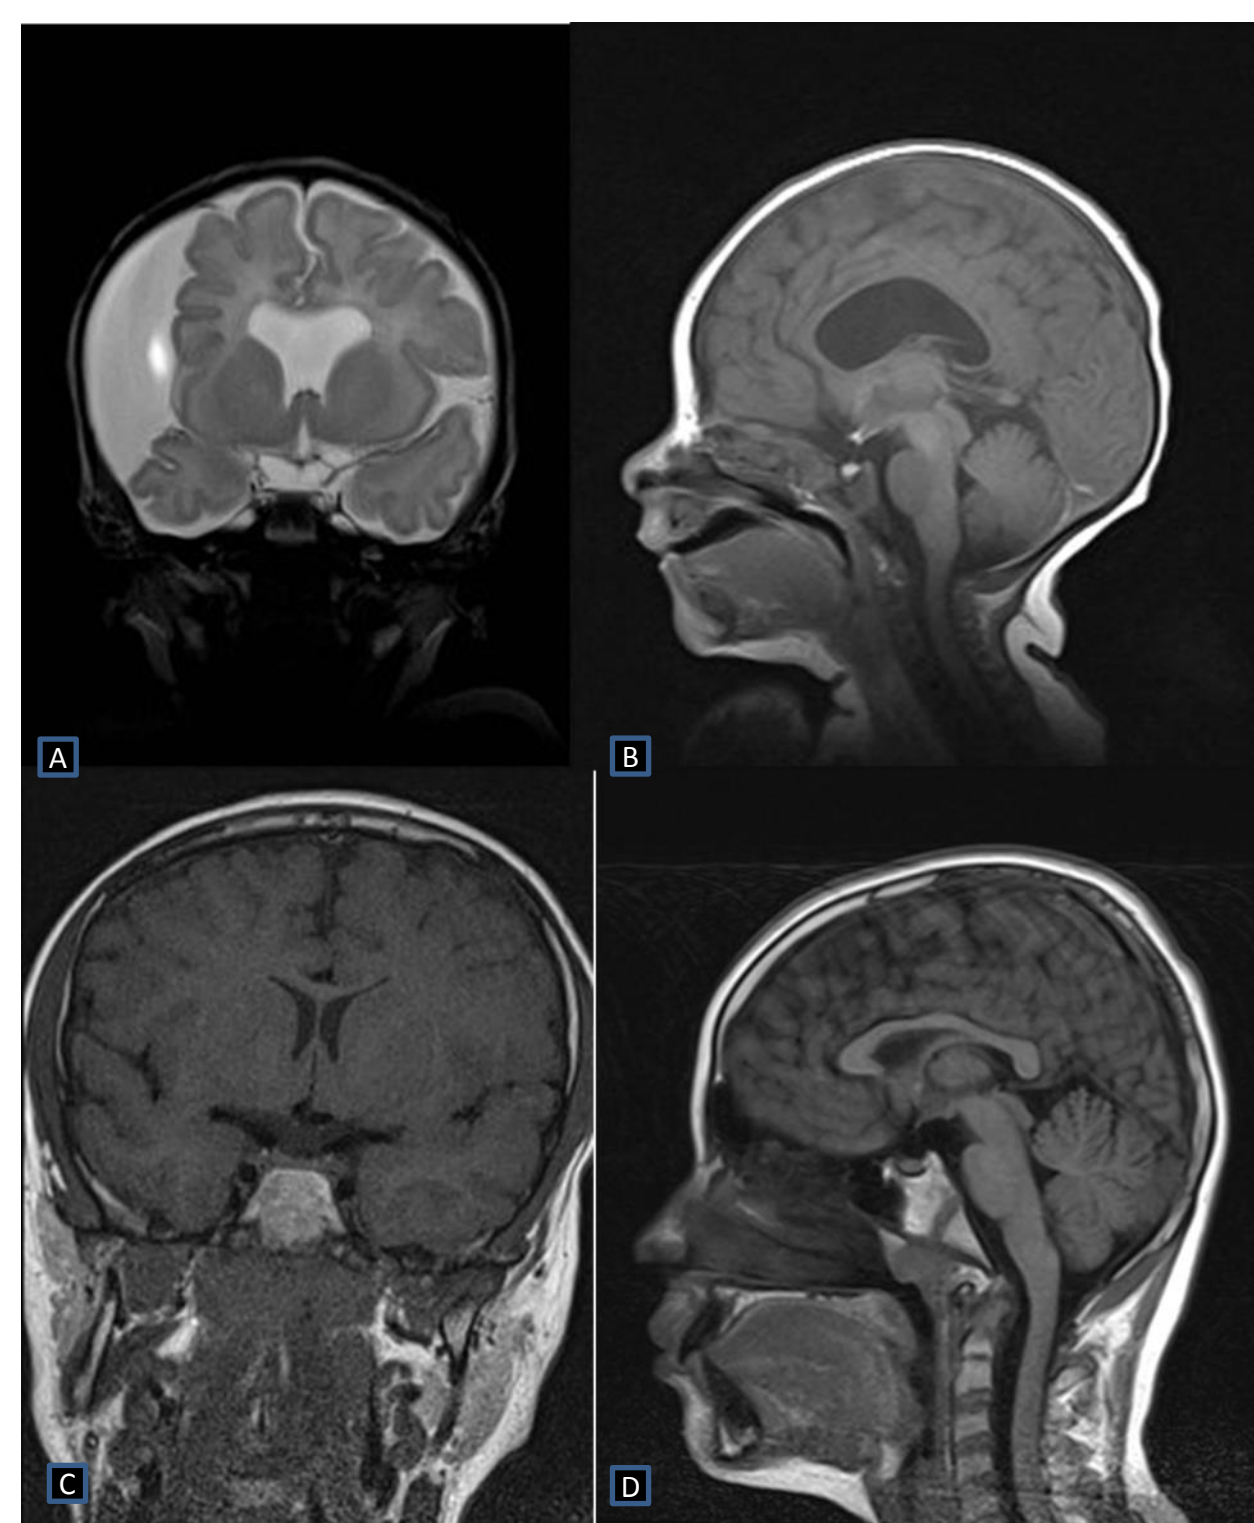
Typical SOD features on MRI Brain: A - Absent septum pellucidum on coronal T2, B - EPP at superior end of stalk on sagittal T1, C - Tiny optic nerves, D - Thin Infundibulum.
